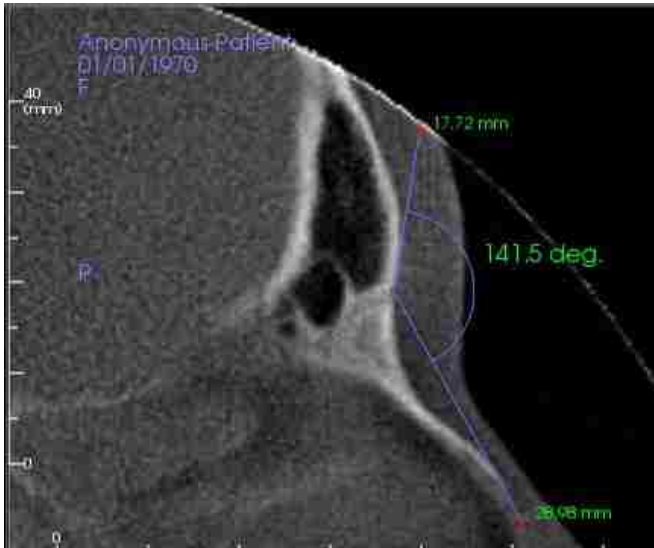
Nasofrontal angle measured from CBCT*
